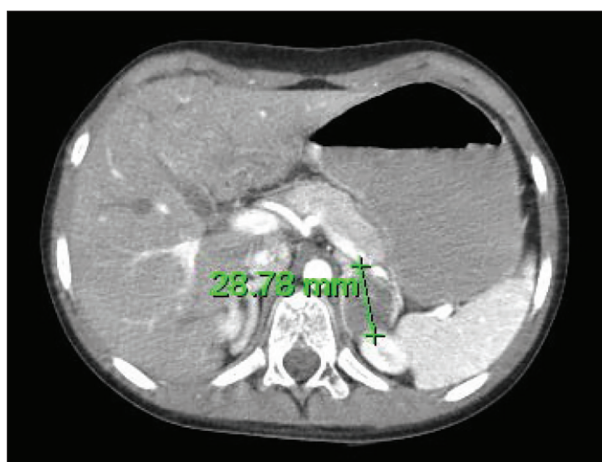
Contrast-enhanced abdominal computed tomography scan shows in the left adrenal gland a solid lesion of diameter of 30 mm, with progressive and dishomogeneous enhancement
